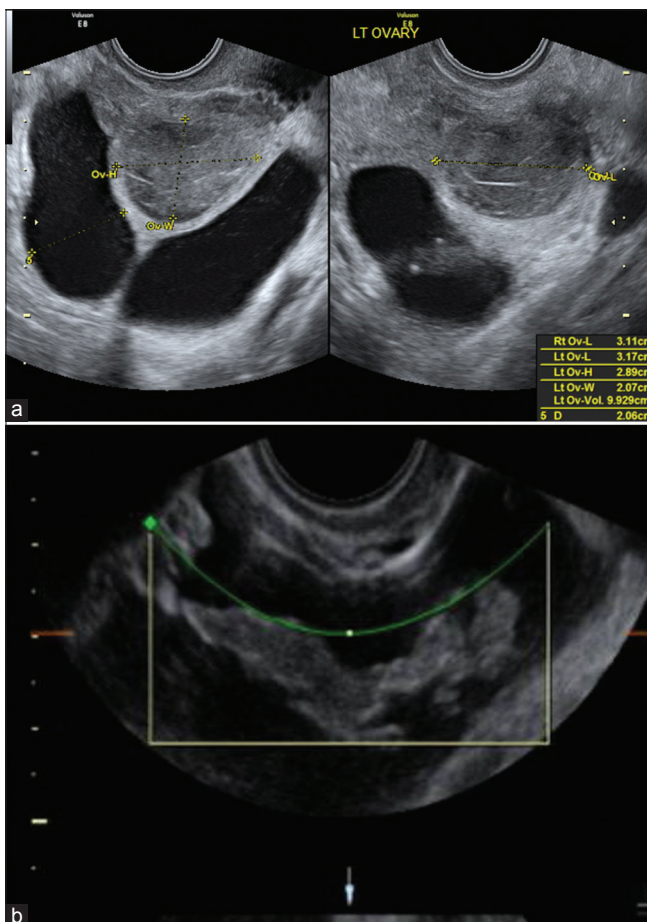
Fallopian tube on ultrasound identified because of (a) Fluid in the tube. (b) Fluid outside the tube – in pelvis
